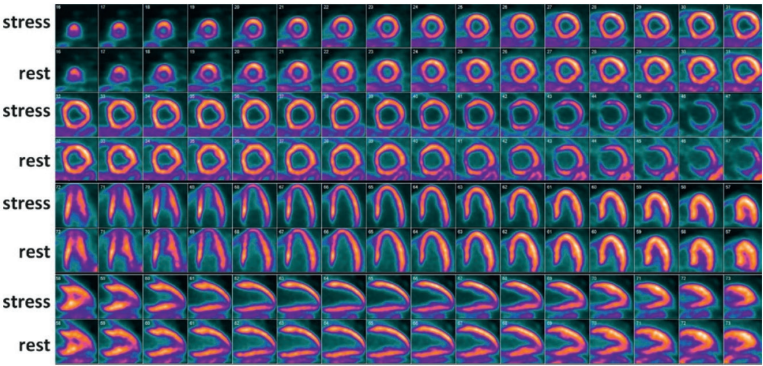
Rest and Regadenoson-stress $[^{13}\text{N}]\text{NH}_3$ myocardial perfusion PET/CT images demonstrate normal myocardial perfusion both at rest and during stress [110].
